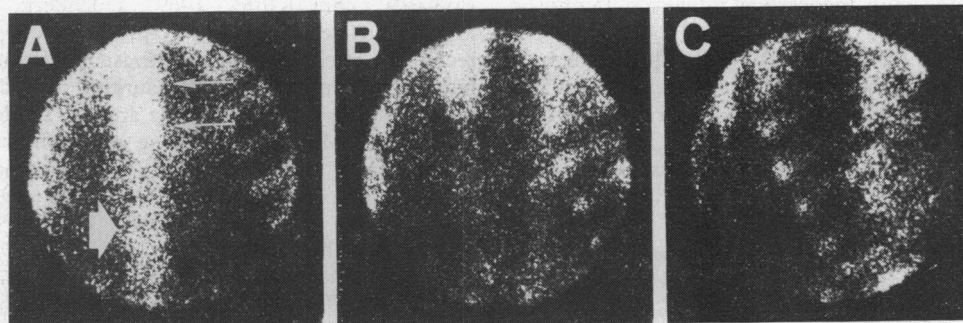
A negative $^{99m}\text{Tc-PYP}$ scintigram. Panel A is an anterior view, panel B a left anterior oblique view, and panel C a left lateral view. Note the uptake in the sternum and vertebral column (arrows point to these structures in panel A). Also note the faint uptake of the $^{99m}\text{Tc-PYP}$ in the ribs.
